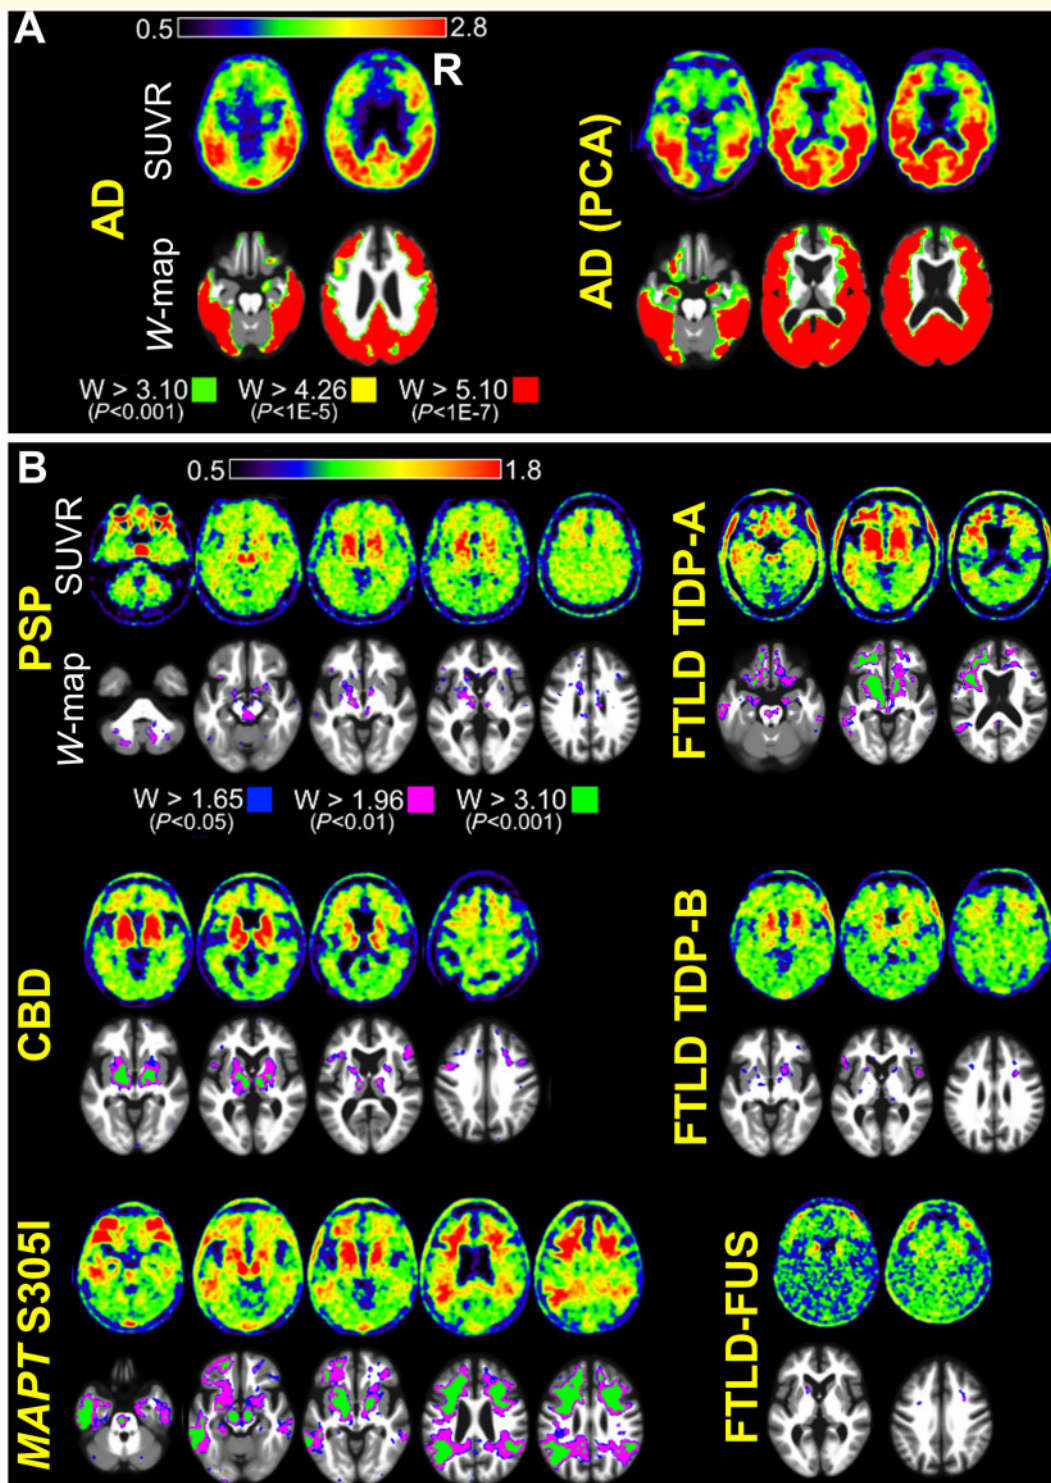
FTP-PET SUVR and W-score map images. (A) Example SUVR and W-map images are shown for patients with primary Alzheimer's disease (AD) neuropathological diagnosis. One patient had a typical amnesic clinical phenotype and the other patient had an atypical posterior cortical atrophy (PCA) phenotype. Patients with primary Alzheimer's disease pathology had marked FTP uptake, and high SUVR and W-map thresholds were chosen to highlight the full range of tracer retention in these patients. Images for all Alzheimer's disease patients are shown in [Supplementary Fig. 1](#). (B) Example SUVR and W-map images are shown for patients with primary autopsy diagnoses of non-Alzheimer tauopathies, FTLD-TDP, and FTLD-FUS. These patients had lower FTP uptake than patients with primary Alzheimer's disease autopsy diagnosis, and lower SUVR and W-map thresholds needed to be used to highlight the areas of tracer retention in these patients. To allow for comparison with the Alzheimer's disease cases, the W-map upper threshold ($W > 3.10$) is the same as the lower threshold used in patients with primary Alzheimer's disease pathology. Images for all patients with non-Alzheimer's autopsy diagnoses are shown in [Supplementary Fig. 2](#).
